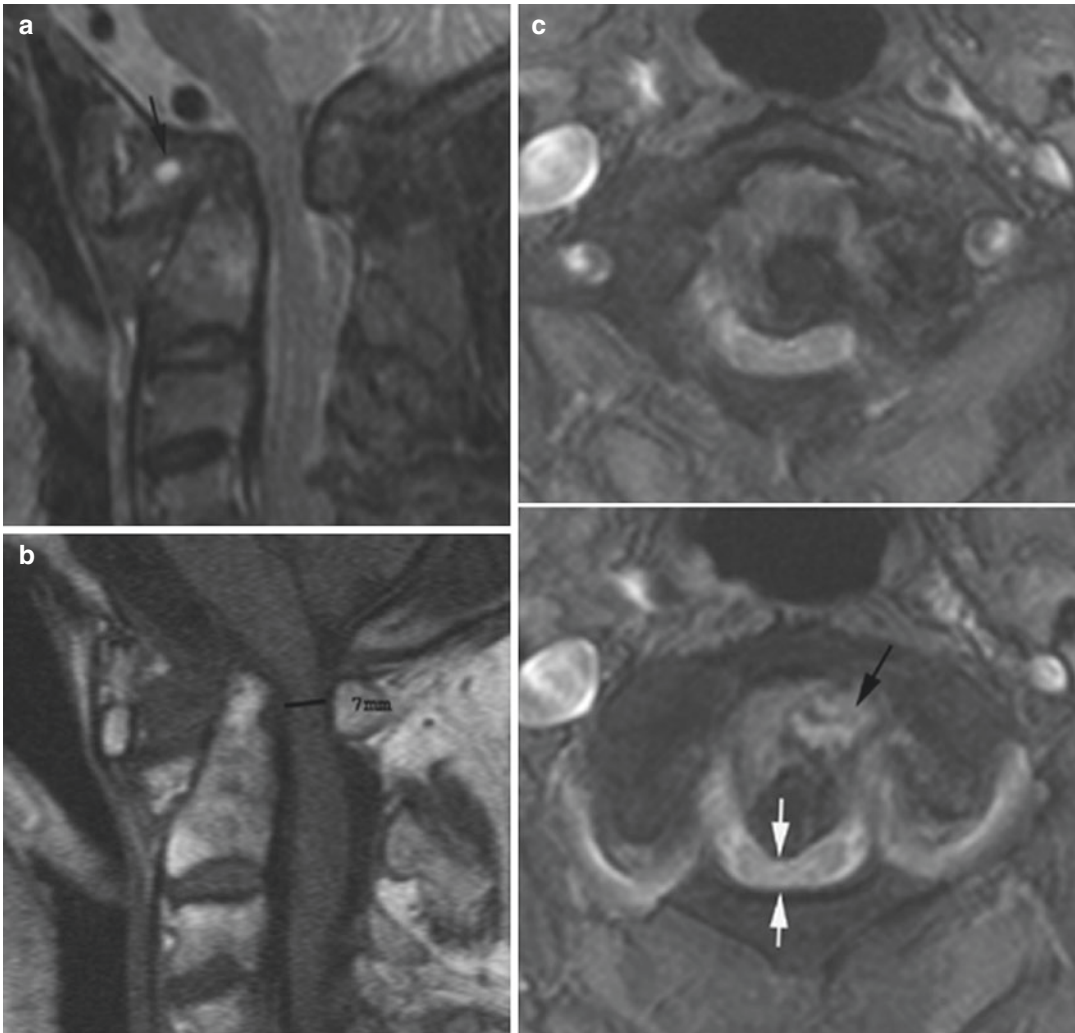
A 69-year-old woman with RA and myelopathy. Sagittal STIR (a), T1-weighted (b), and axial T2-weighted, fat-saturated images of the dens (c) demonstrate erosion of the dens (image a, black arrow) with protrusion of the tip of the dens into the foramen magnum, resulting in stenosis of the canal and impingement of the upper cervical
